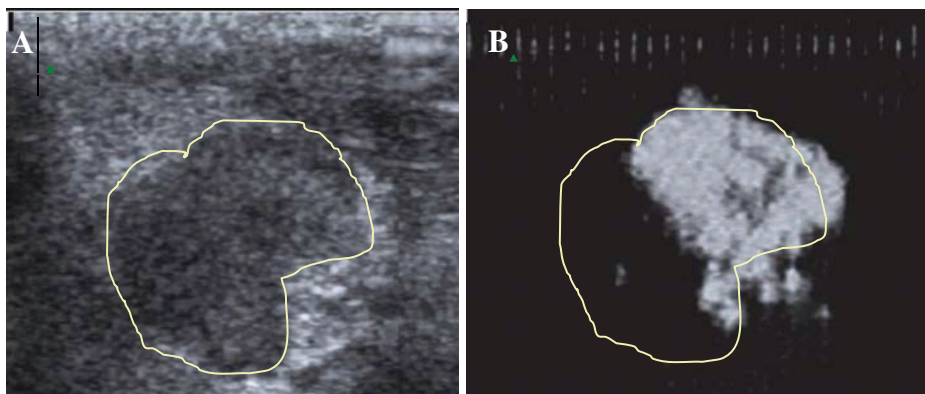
(A & B) Ultrasound images acquired with a standard ultrasound technique (A) or with harmonic imaging (B) of the popliteal node of a rabbit with Vx2 tumor in the calf show the filling of only the normal portion of the node (B). The entire node is seen with standard ultrasound [overlay in (A)]. Note that with harmonic imaging that severely suppresses tissue signal and shows only microbubbles (B), only the normal portion of the node fills with contrast. (Adapted from Fig. 3 in (13) with permission.)
